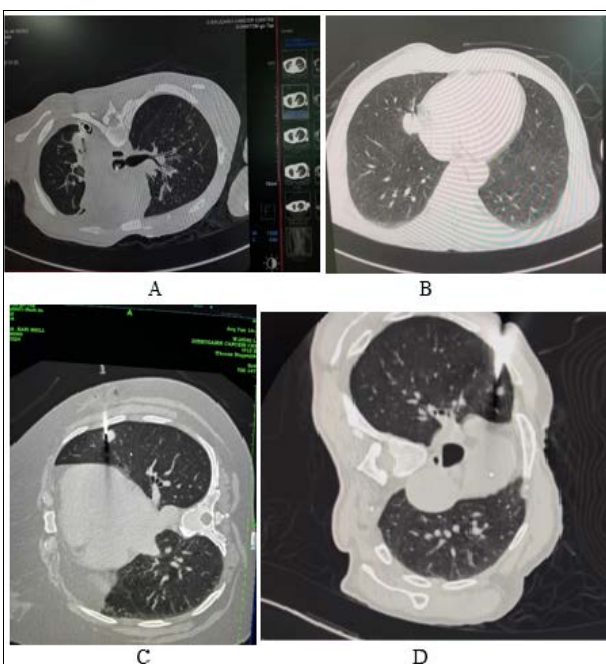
a, b, c, d: Showing CT guided biopsy of small pulmonary nodules in varied and difficult locations accessed with prior planning and patient positioning. The small lung nodules had to be sampled to rule out possibility of metastatic disease and hence guide the multidisciplinary team.
